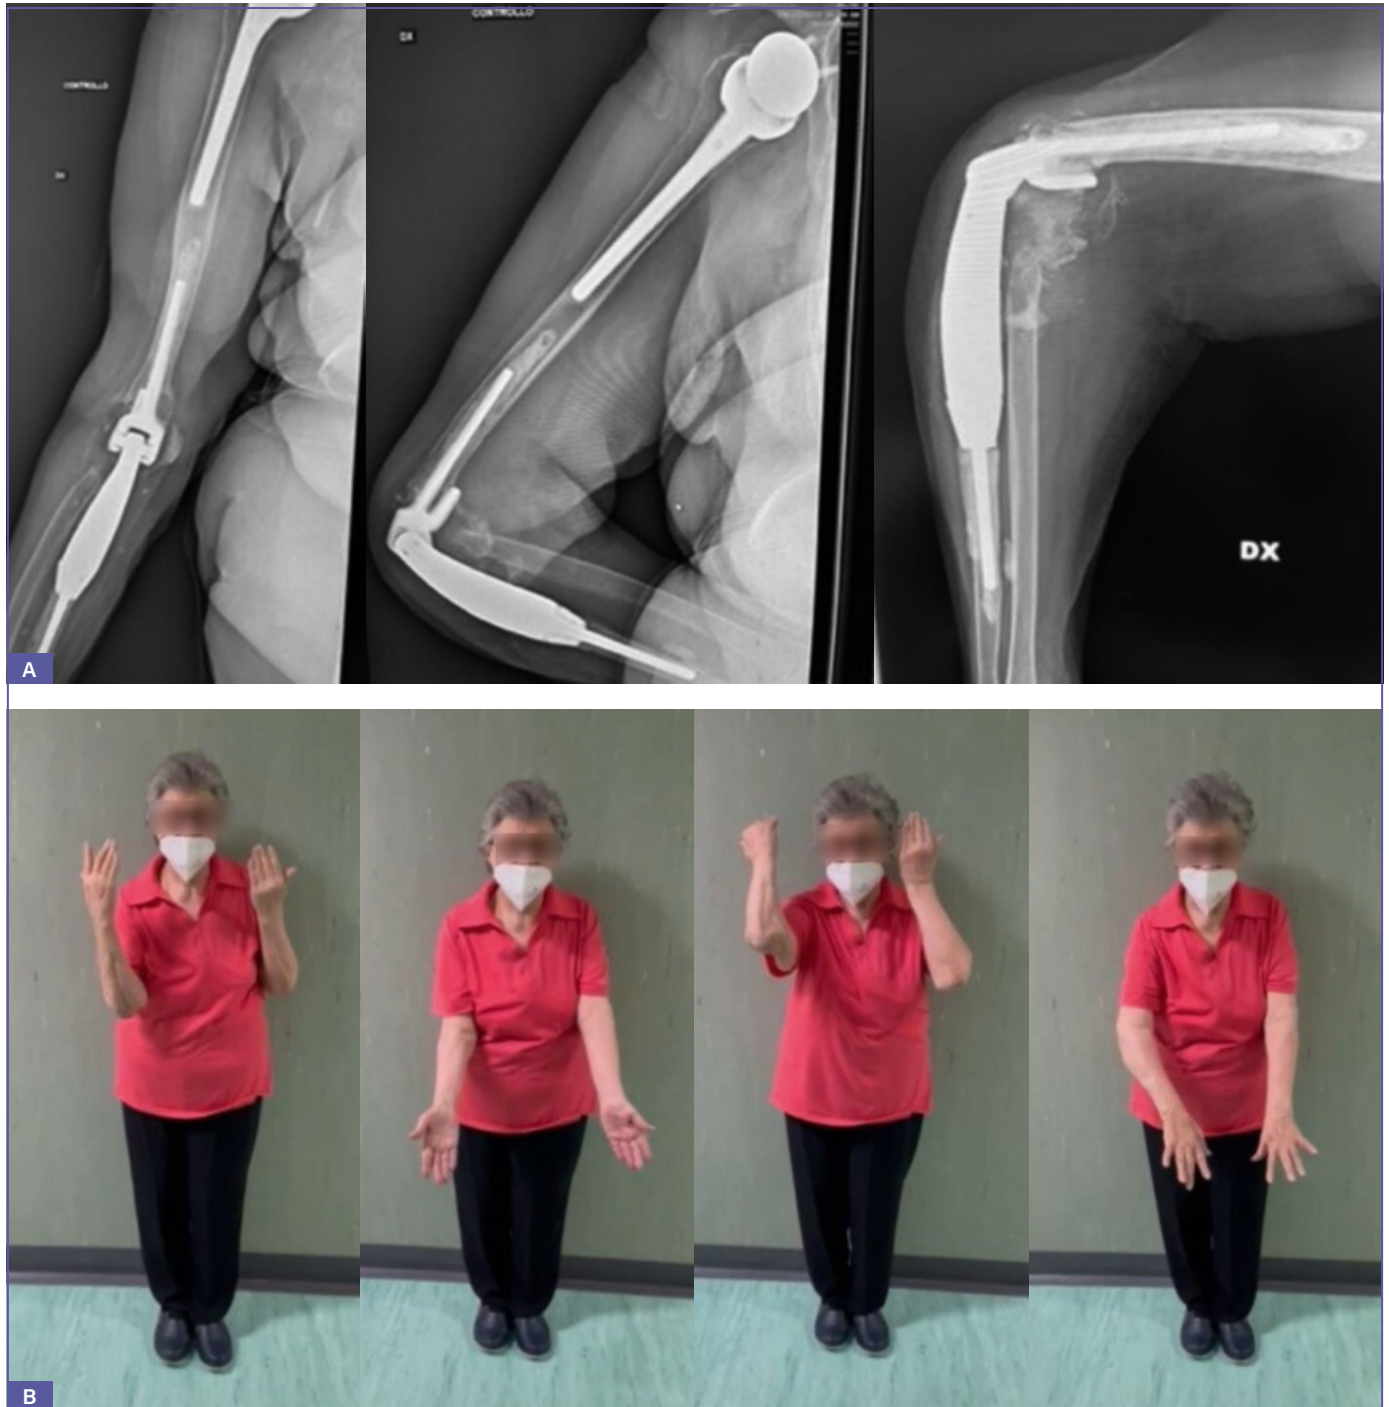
A) radiographic check-up at 12 months; B) clinical check-up at 12 months, slight deficit in flexion and extension of the right elbow without painful symptoms.
